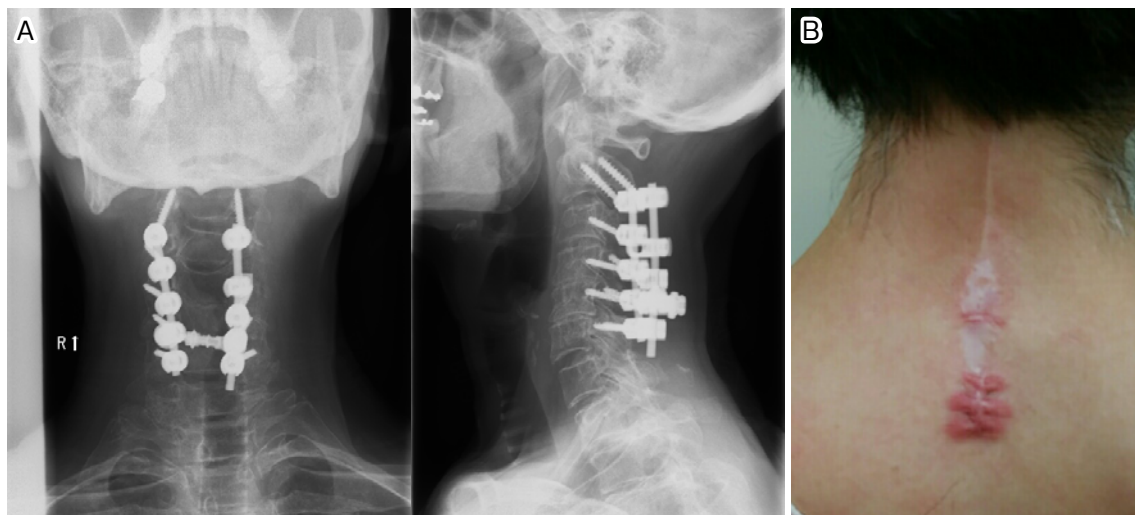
A: Anterior–posterior and lateral radiograph after the second surgery. B: Clinical photography indicates keloids in the surgical scar.
